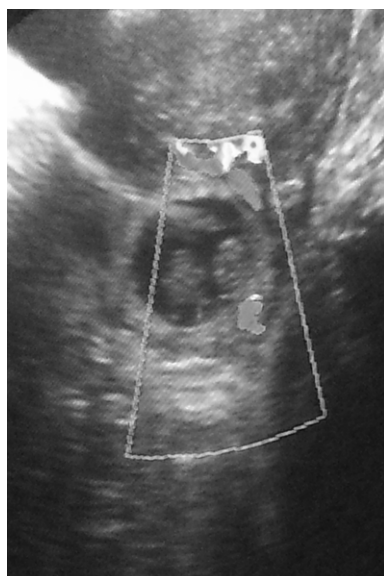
Endovaginal ultrasound revealed an empty uterus and 2 live fetuses with cardiac activities in the left adnexa.
